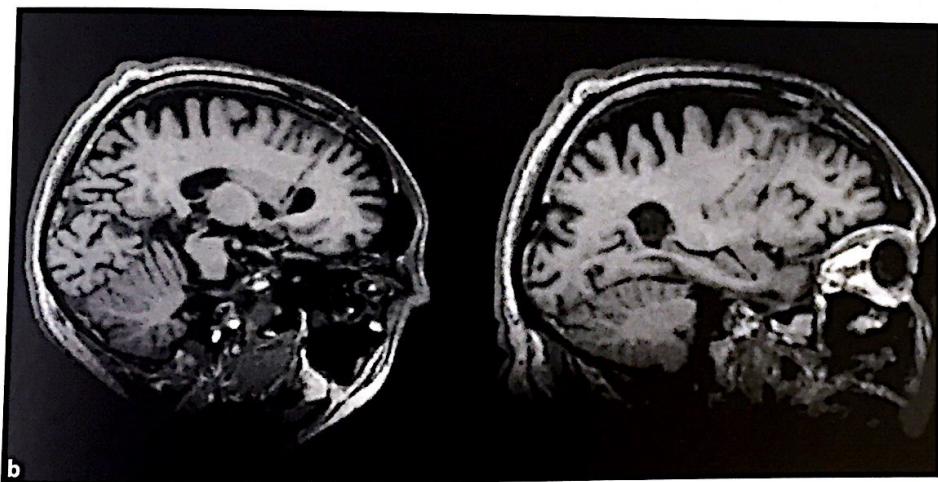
3-dimensional magnetic resonance images generated by the neuronavigation workstation from contrast-enhanced T1 MPRAGE sequence. a Stereotactic planning of procedure n = 14. First row: projection of NCc (yellow/white) and Pu (red/grey) stereotactic tracks on a multiplanar view; cross points indicate the location of targets. Second row: trioblique view of NCc stereotactic tracks. Third row: trioblique view of Pu stereotactic tracks. Bottom right corner: image of the patient's scalp surface showing the location of the entry points for caudate and putaminal sets of the location of the entry points for caudate and putaminal sets of stereotactic tracks. Planning of caudate grafting involves two stereotactic tracks having a common precoronal point of origin and the inferior extremities located, respectively, in the anterior and posterior portion of NCc, not below the bicommissural plane. These tracks
